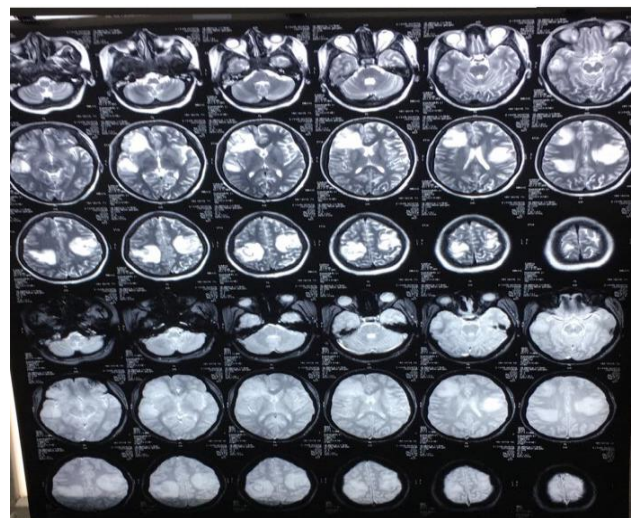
MRI brain film which was suggestive of metastasis.
